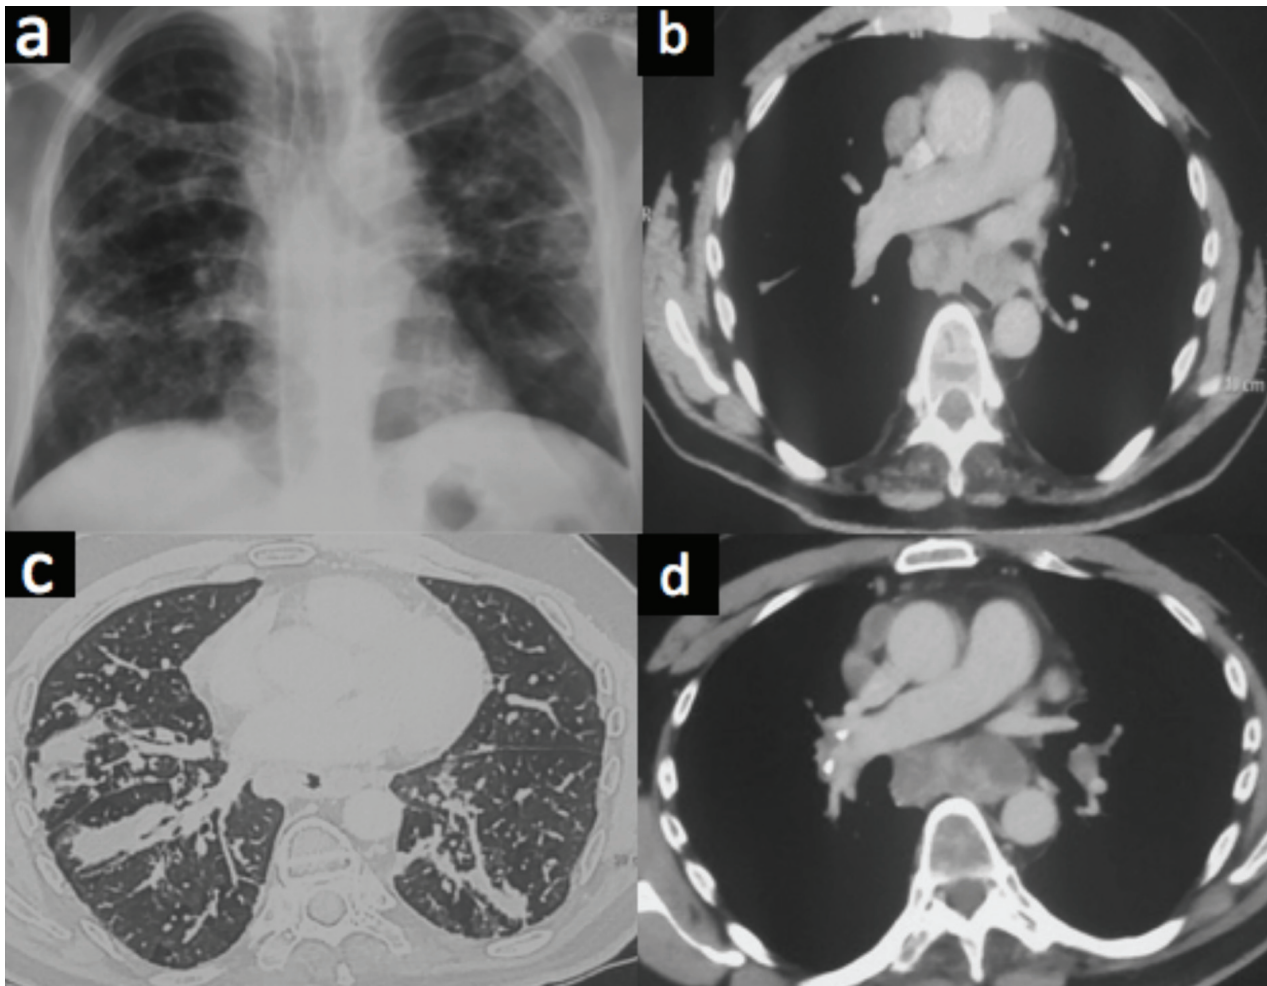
X-ray chest showing bilateral reticulonodular opacities with mediastinal widening. b) CT chest showing enlarged subcarinal lymphadenopathy. c) High resolution CT showing bilateral reticulonodularity in bronchovascular distribution with septal nodularity. d) Repeat CT showing increase in the size of subcarinal lymph nodes as compared to Figure 2b
